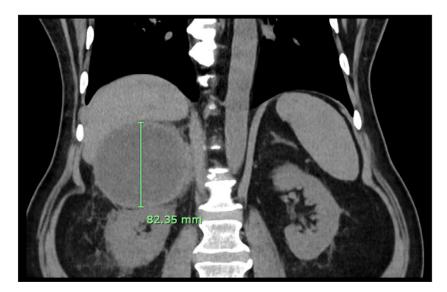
Repeat CT AP contrast-enhanced scan, organized as an outpatient, six months following discharge. Demonstrating a decrease in size of the hematoma; 91 \times 82.35 \times 84 mm transverse, craniocaudal, and anteroposterior measurements respectively with a mean density of 21HU.
